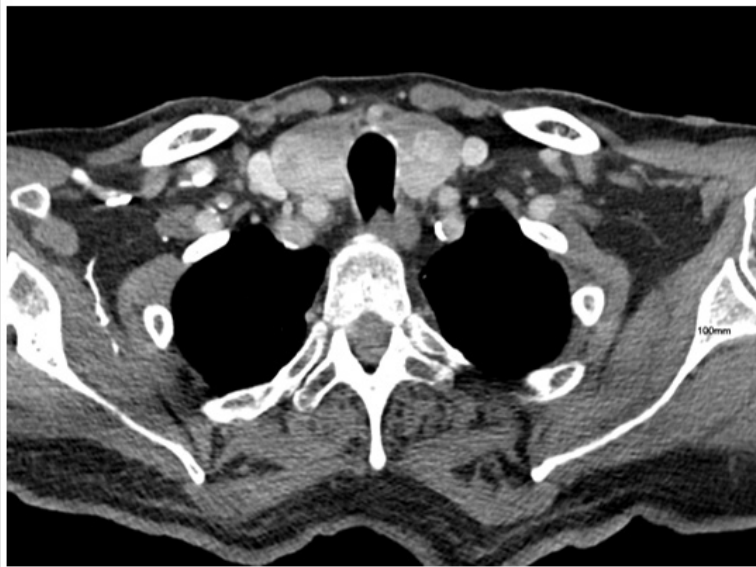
CT of the neck demonstrating no lymphadenopathy or areas concerning for metastases.
